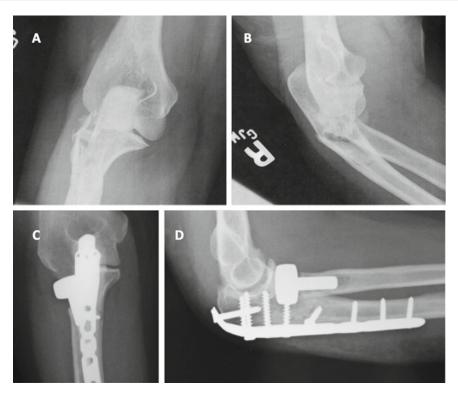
Posterior Monteggia with radial head fracture. Anteroposerior (a) and Lateral (b) radiographic views demonstrate posterior Monteggia at metaphyseal level (Jupiter IIB) with associated comminuted radial head fracture. Postoperative Anteroposterior (c) and Lateral (d)
